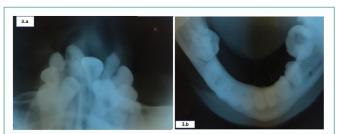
Maxillary and mandibular occlusal radiograph. a) Maxillary occlusal radiograph presented with crowded maxillary teeth, retained deciduous and missing permanent teeth. b) Maxillary occlusal radiograph presented with missing 45, 47 and altered crown morphology in 36 and 46, Coronal radiolucency in 46.
